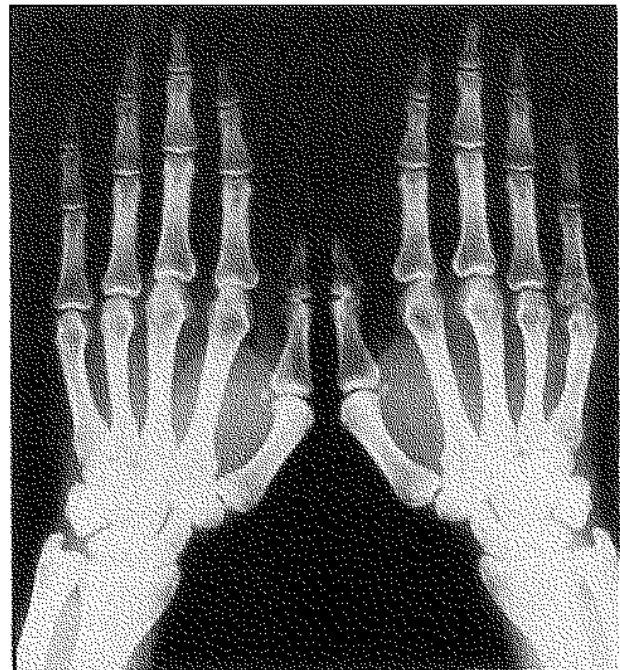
Radiograph showing lytic lesions in the base of the proximal phalanx and the metacarpal head of the fifth MCP-joint.
